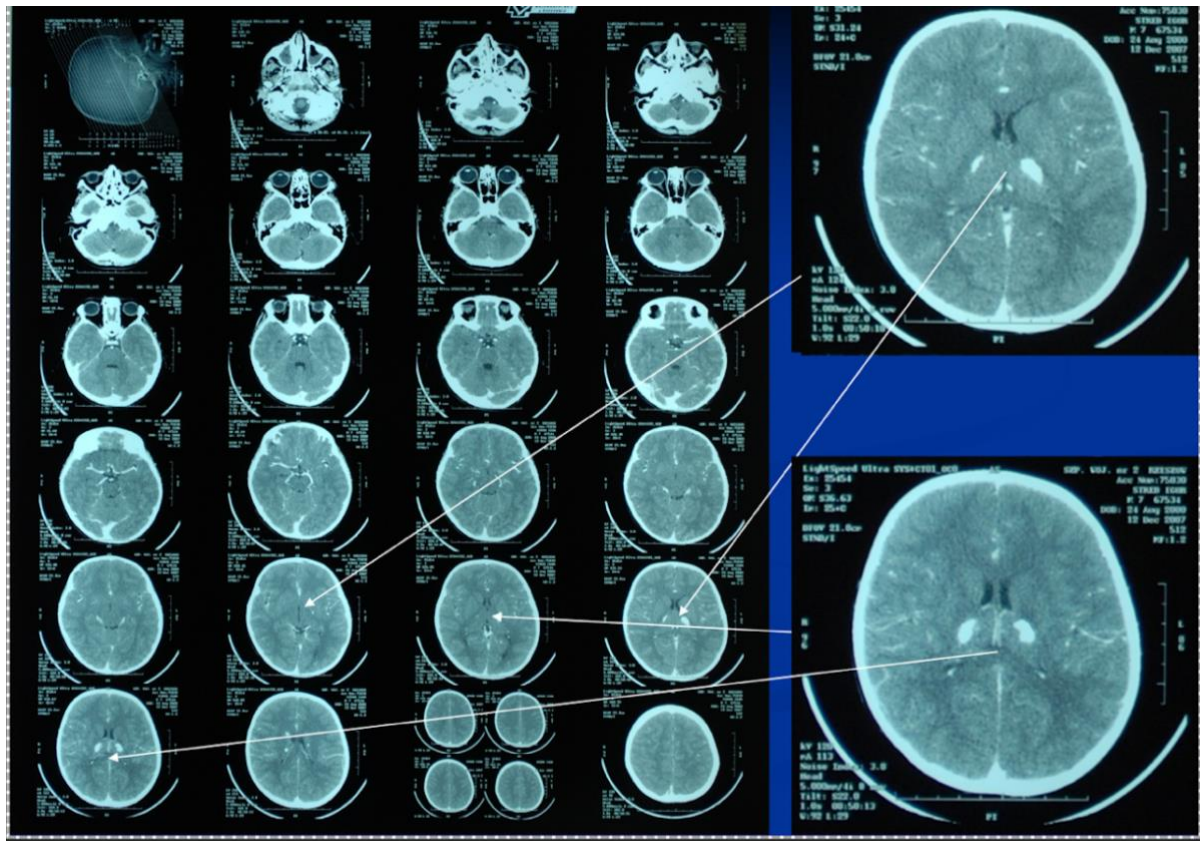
A CT scan of the patient's 7-year-old brother revealed bilateral calcifications measuring 11×6 mm in the thalamic region
